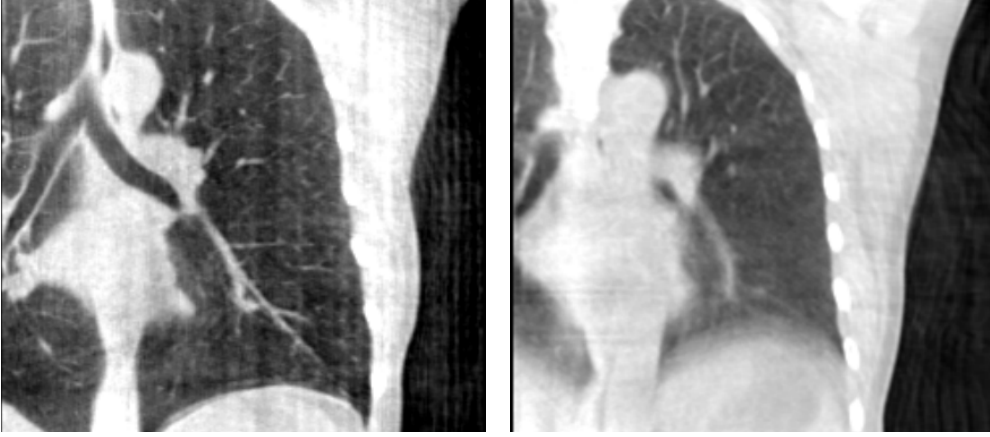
Cone-beam CT images of the same patient using static cone-beam CT image reconstruction. Reconstruction from breath-hold acquisition of 95 projection images (left) and from free-breathing acquisition of 670 projection images (right). Figure re-printed from [B3].
